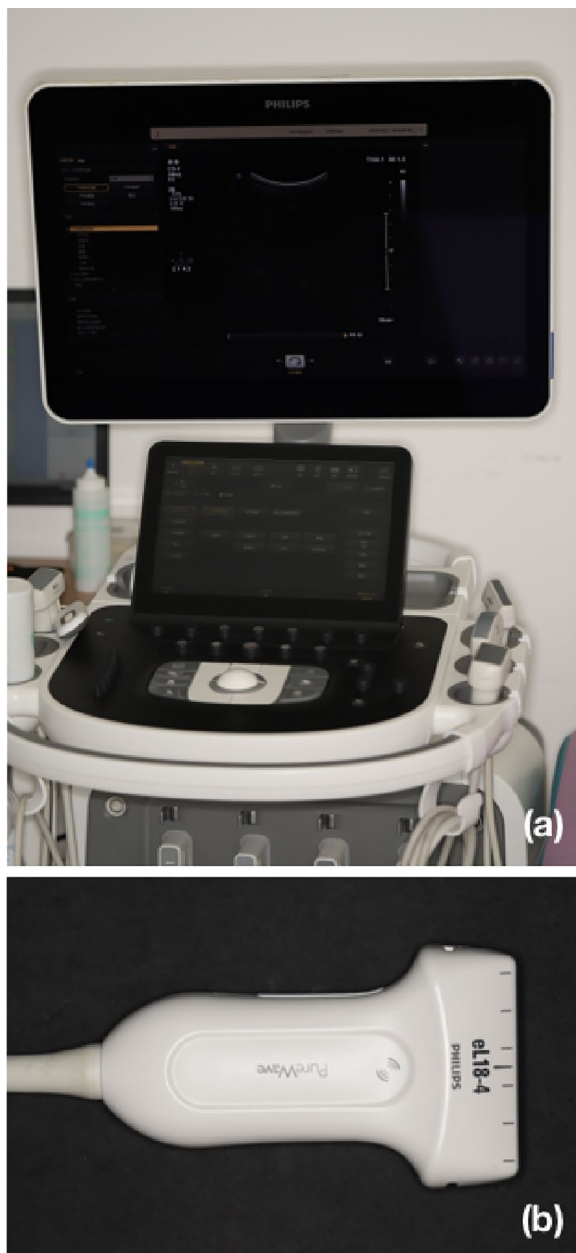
Ultrasound instruments used for these analyses, that were utilized in this study. a Philips ultrasound instrument. b eL18-4 ultrasound probe
